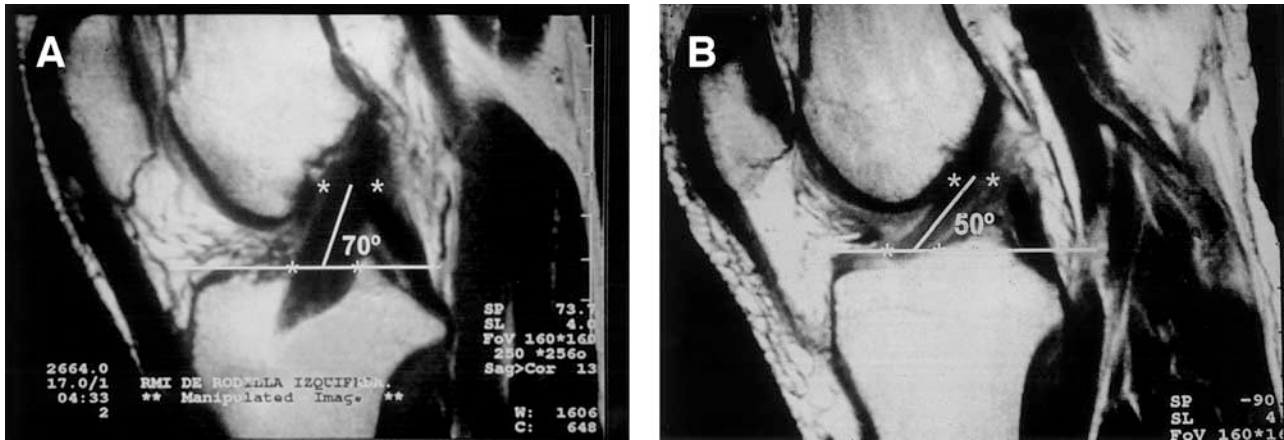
Comparison of sagittal obliquity between a reconstructed patient and a normal control. (A) Sagittal MRI from case number 2 at 28 months after reconstruction showing 70° of sagittal obliquity. (B) Sagittal MRI from normal control number 3 with 50° of sagittal obliquity.
